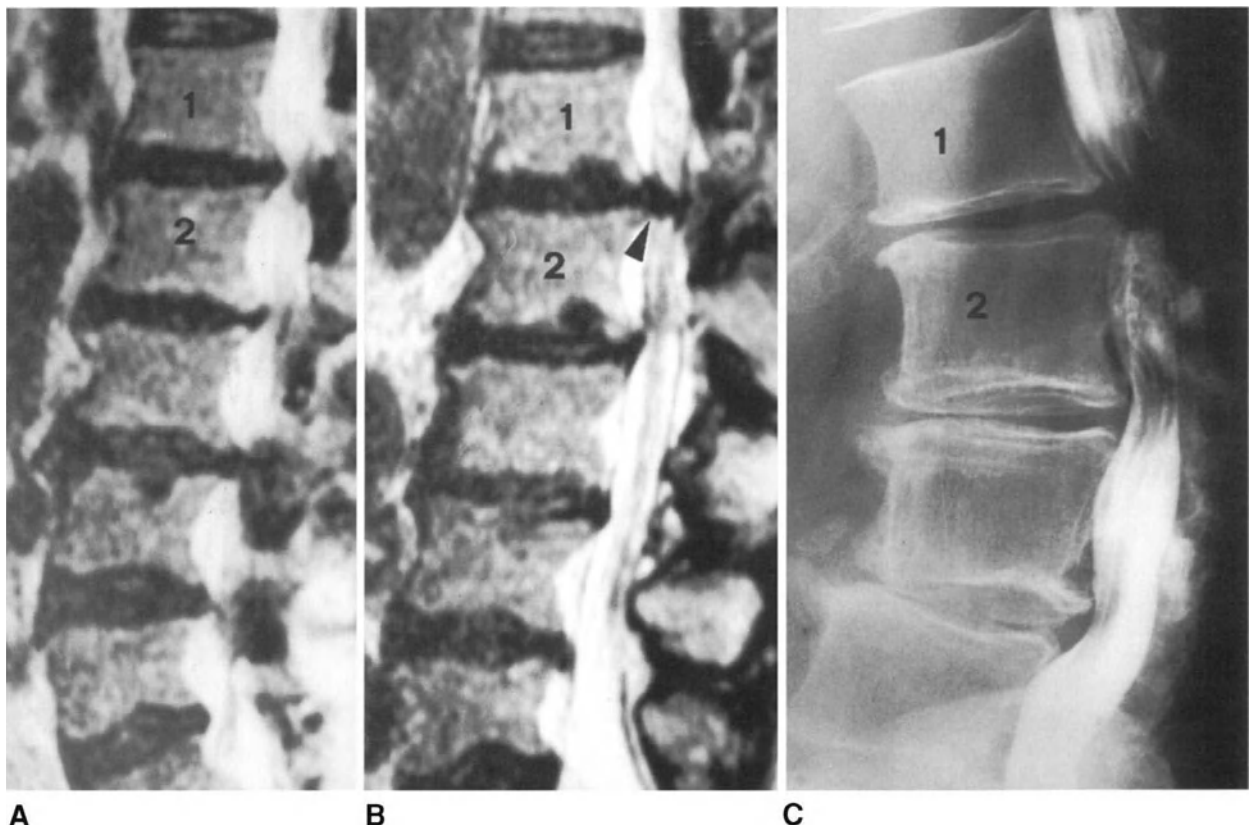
MRI scans and myelogram of a patient with lumbar stenosis who had inadequate surgical decompression. (A) Preoperative spin-echo T2-weighted sagittal image showing stenosis at multiple levels, between L1 and L5, and concomitant disc herniation at L3-L4 level. Bilateral laminotomy was performed at L2-L3, L3-L4 and L4-L5 levels, along with discectomy at L3-L4. (B) Turbo spin-echo T2-weighted sagittal image performed 11 months after surgery, showing compression of the nervous structures at L1-L2 level (arrowhead), due to stenosis of the spinal canal and disc herniation which were already present, although producing a less severe neural compression, prior to surgery. (C) Myelogram showing a complete block of the contrast medium at L1-L2 level.
